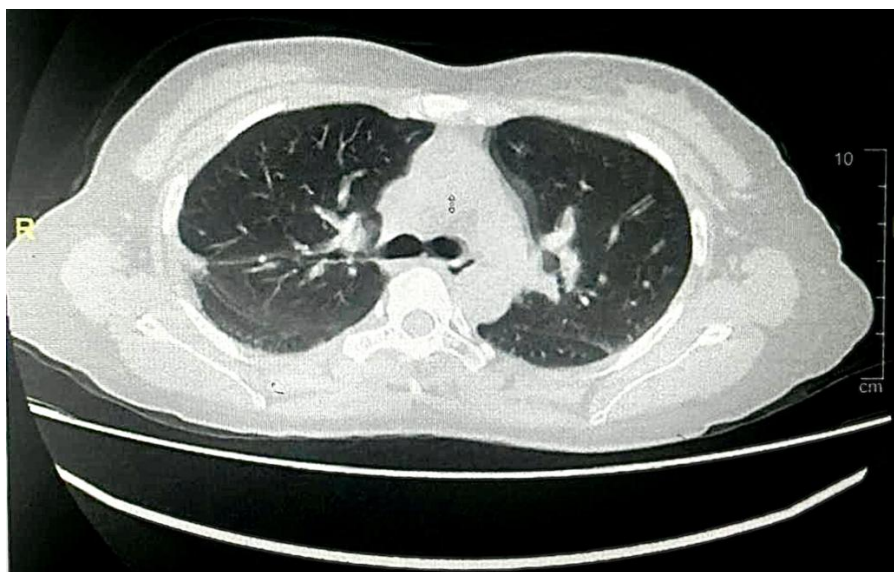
High-resolution computed tomography (HRCT) of the chest demonstrating a focal ground-glass opacity in the apical segment of the left upper lobe, without associated pleural effusion or significant mediastinal lymphadenopathy.
